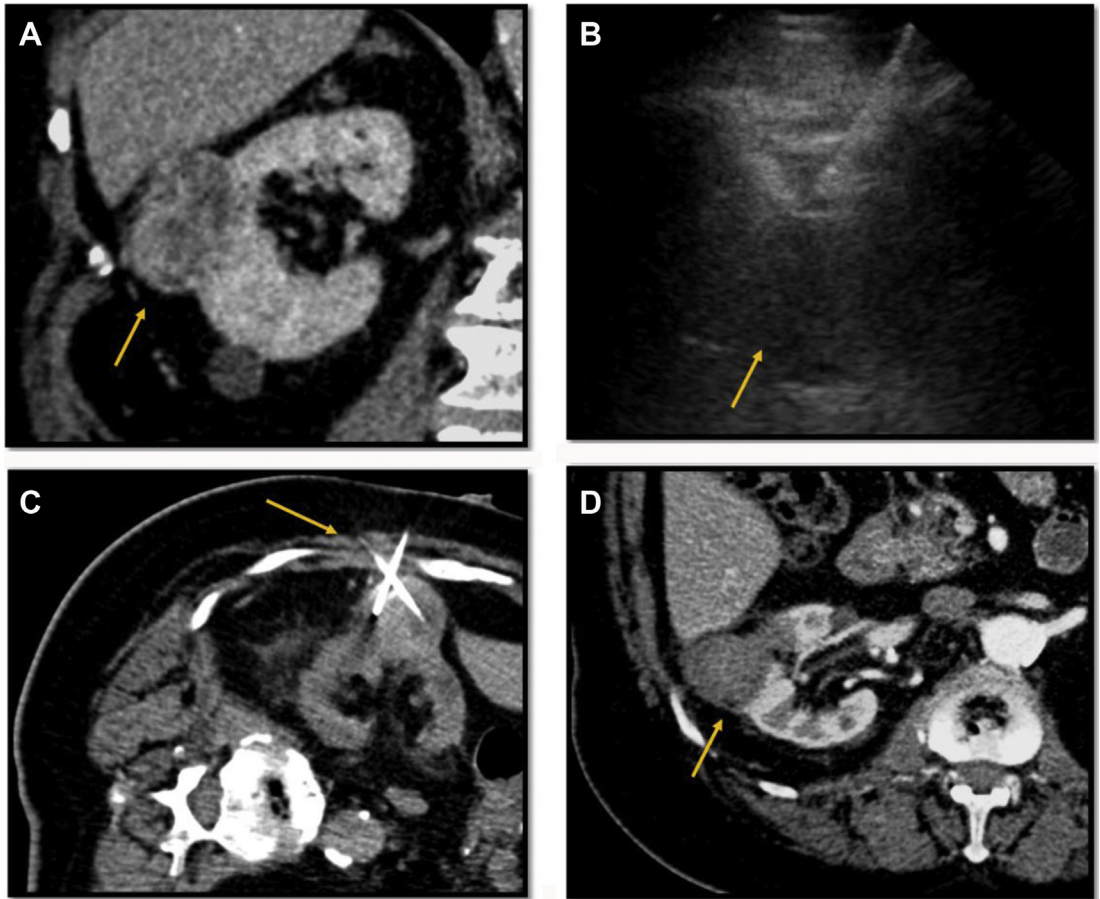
An 86-year-old man with 4.5-cm exophytic clear cell RCC in the right kidney (arrows). Preablation CT (nephrographic phase) shows tumor enhancement (A). Two RF probes placed into the tumor under US and CT guidance (B, C). Postablation CT (corticomedullary phase) confirms successful ablation with no residual enhancing tumor (D).
